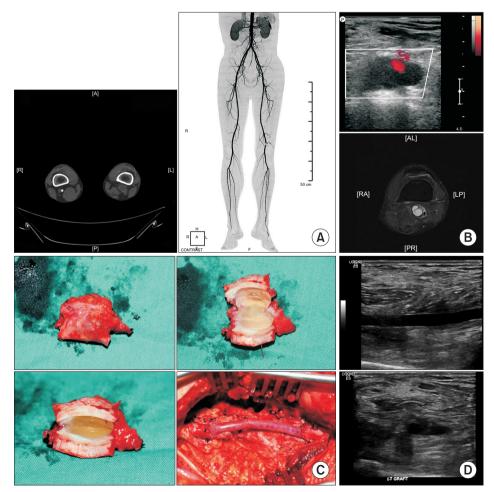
A 44-year-old male patient who was suffering from left leg claudication was diagnosed with left popliteal artery adventitial cystic disease and underwent left distal superficial femoral artery-popliteal artery interposition with ipsilateral great saphenous vein. (A) Preoperative computed tomography angiography, (B) preoperative duplex ultrasonography (DUS) and magnetic resonance imaging, (C) operative sample and field photograph after interposition, (D) postoperative follow-up DUS.
